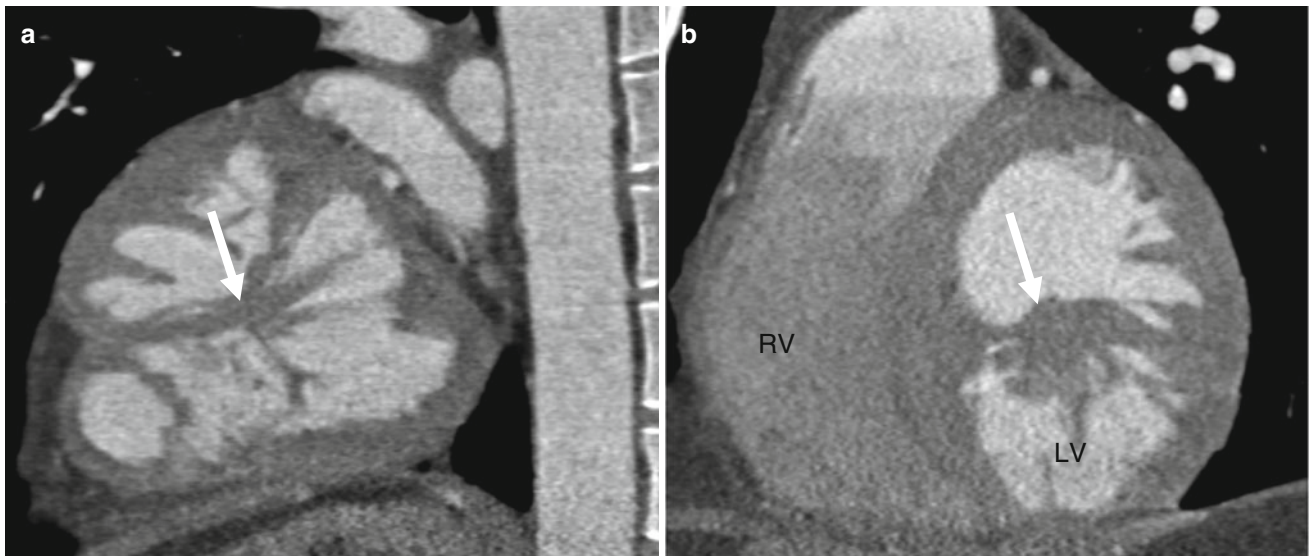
Left ventricular noncompaction (LVNC) in a 22-year-old patient presenting with a new-onset heart failure. Panel (a) a long-axis two-chamber computed tomographic (CT) view. Panel (b) a short-axis CT image. Note the thickening of the left ventricular wall with very prominent
